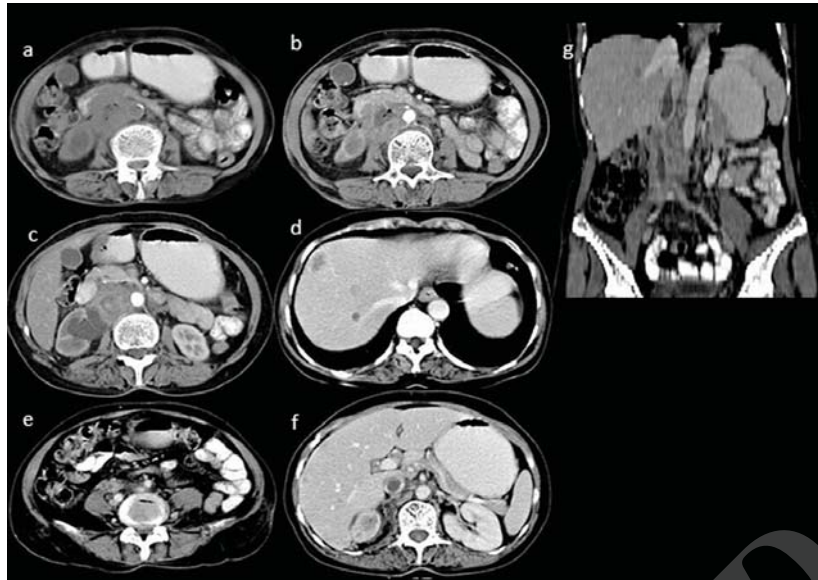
A 72-year female presented with pain in abdomen, distension of abdomen and pedal edema over a period of 3 months. Plain axial CT scan of abdomen; a) Reveals a predominantly hypodense mass lesion involving the IVC. Contrast enhanced CT scan reveals; b) Heterogeneous enhancement of the caval mass with central necrosis. The mass is seen infiltrating the posterior wall of third part of duodenum. Encasement of aorta is also seen; c) The mass lesion is encasing the right renal hilum and proximal ureter causing moderate dilatation of pelvicalyceal system of right kidney; d) Multiple hypodense metastatic foci are seen in the liver. All three hepatic veins are patent; e) Right common iliac vein thrombosis. Postcontrast axial; f) Coronal multiplanar reconstruction ; g) Reveal a hypodense non enhancing bland thrombus in the transhepatic IVC.
